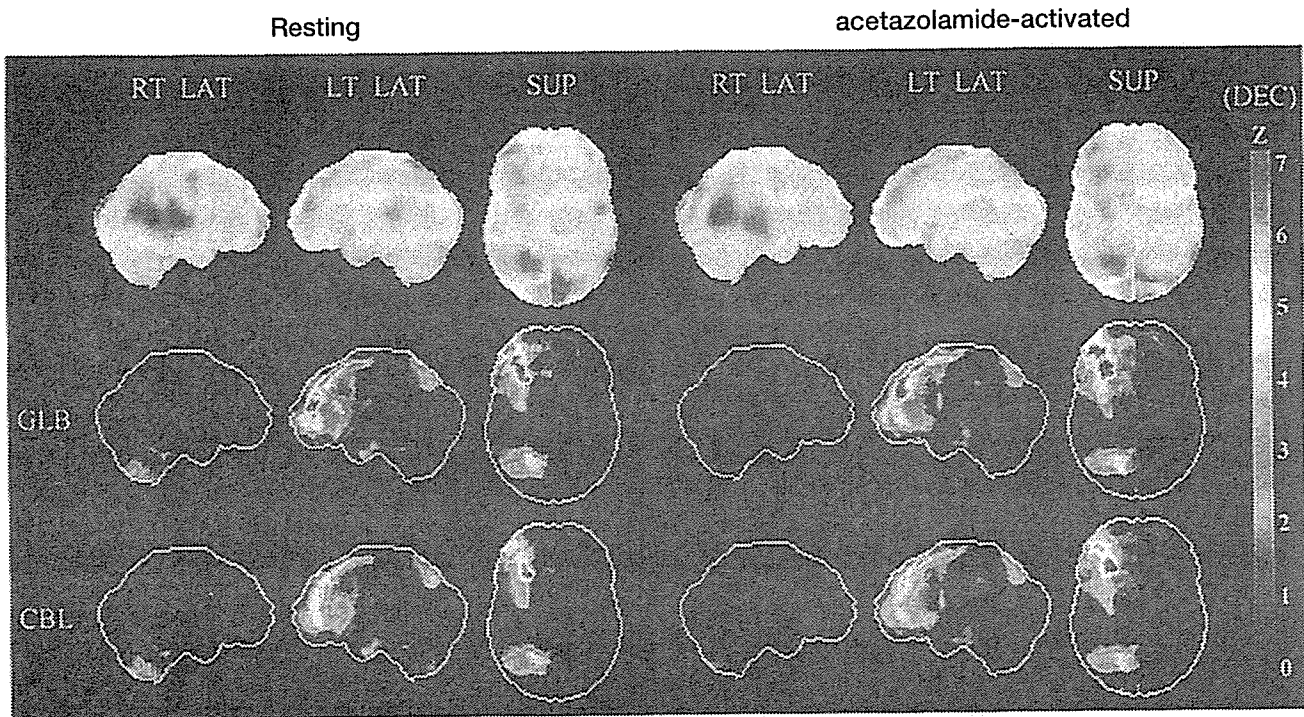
図 4-6 の症例での術後脳血流 SPECT の Z score 画像解析
